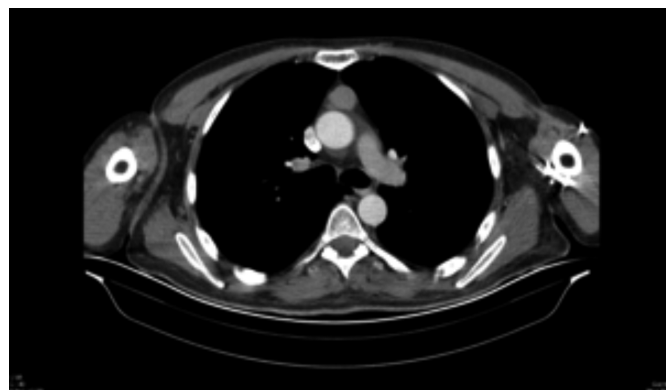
A mass lesion of approximately 25×19 mm in the anterior mediastinum on computed tomography).
